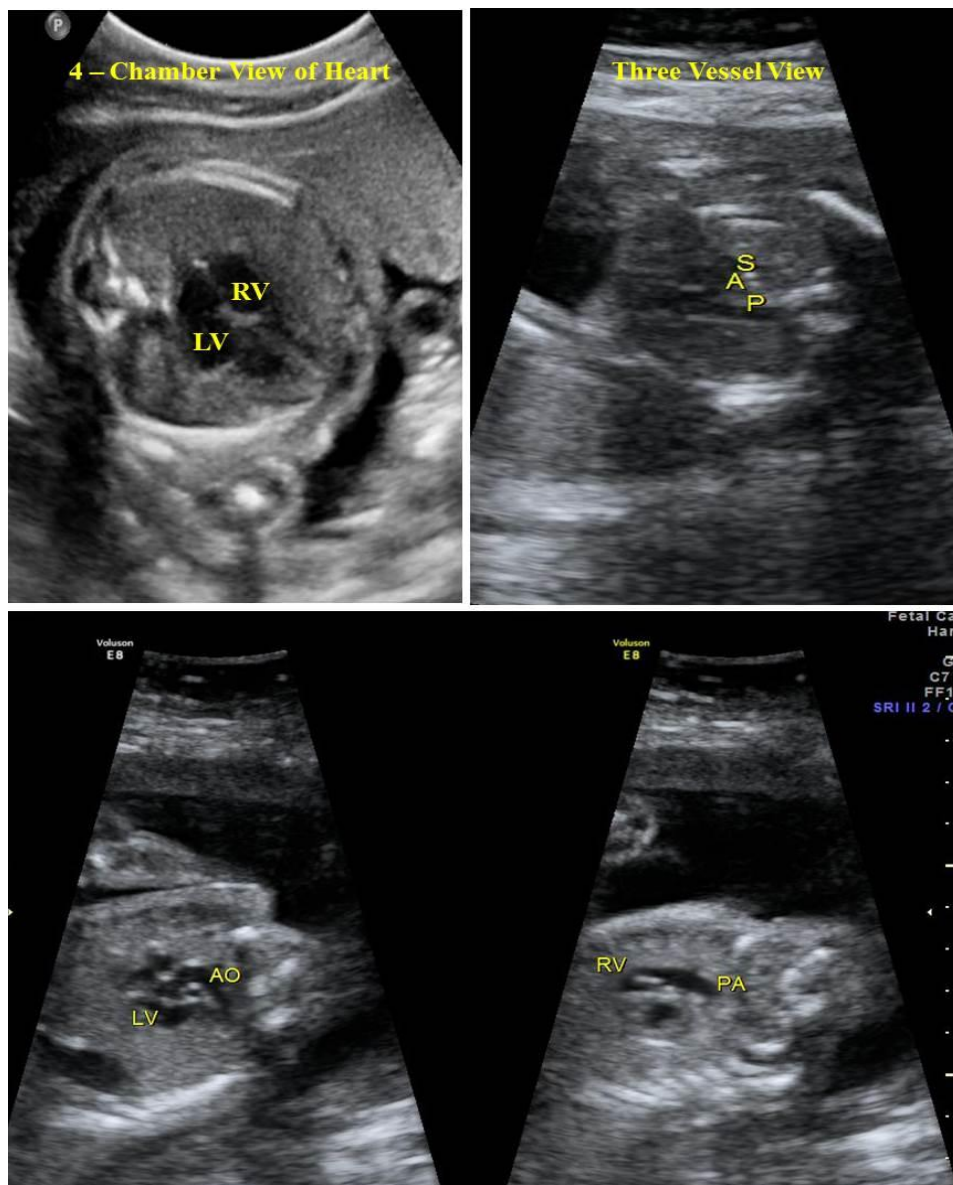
Ultrasonographic observation of aorta and pulmonary trunk(RV- Right Ventricle, LV- Left Ventricle, S - SVC, A - Aorta, P - Pulmonary Trunk)
